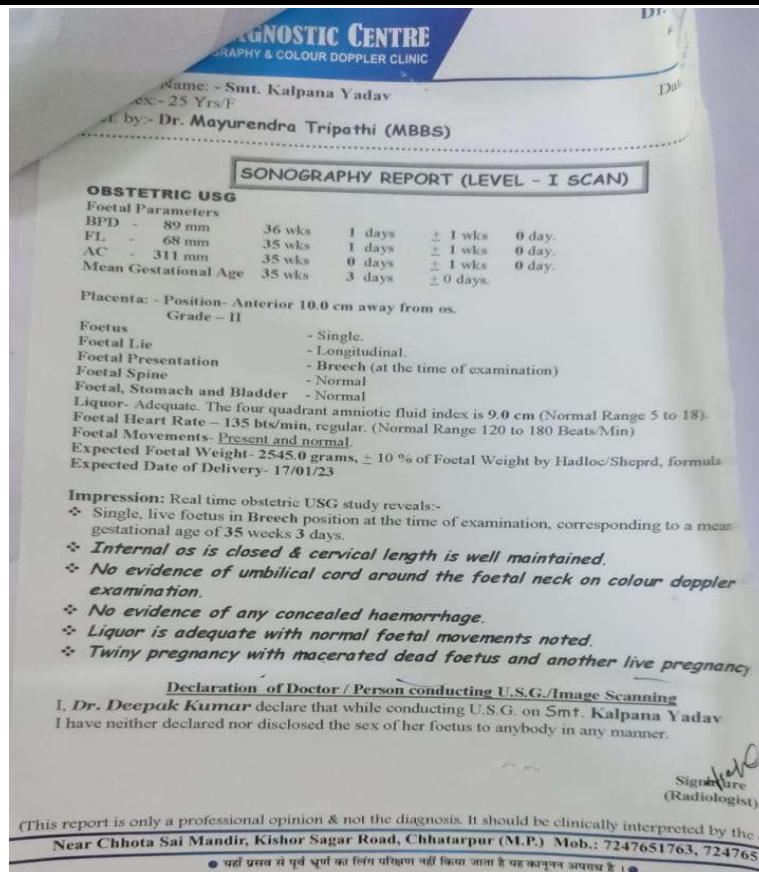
Ultrasonography of the patient at 35.3 weeks of gestation
